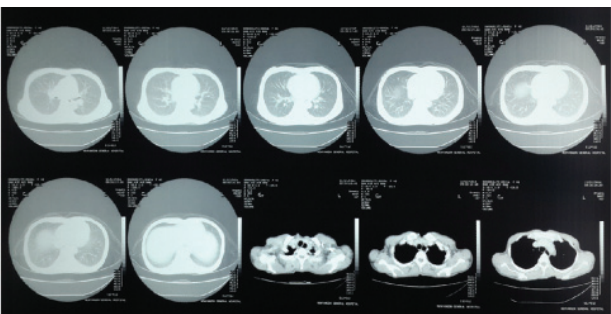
CT scan revealing no thymic tumor
